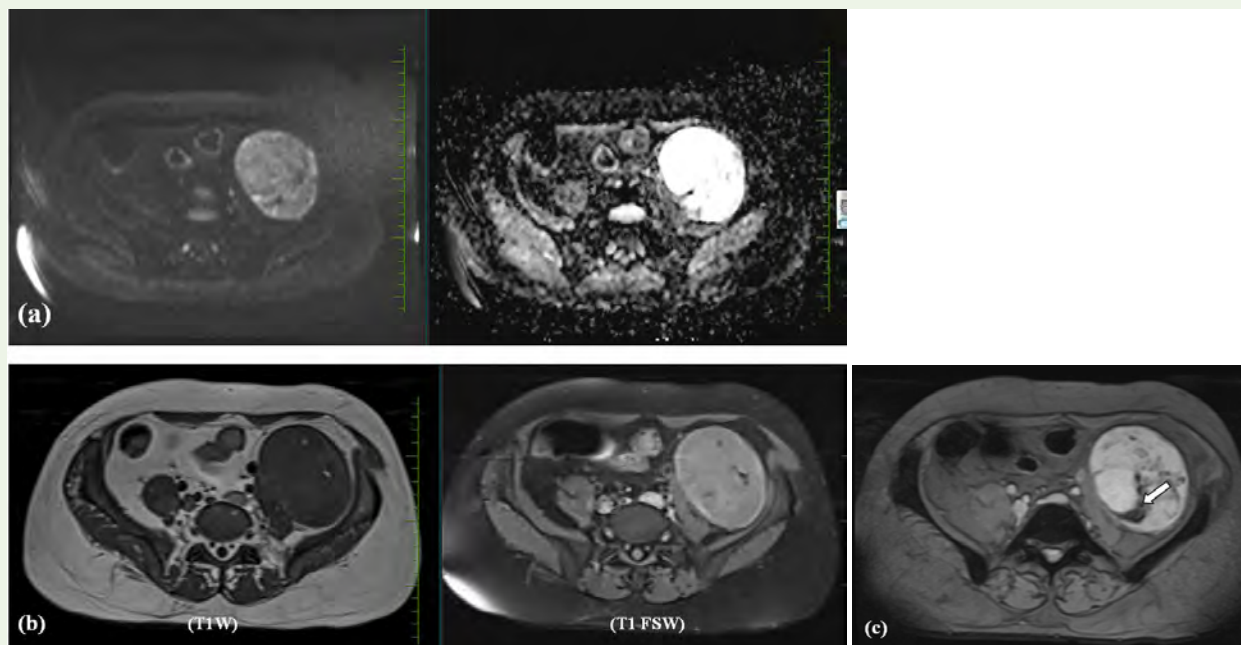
(a) The lesion shows facilitated diffusion with few areas of true diffusion restriction on DWI and (b) few T1 hyper-intense foci which suppress T1 Fat saturation images represent fatty foci and (c) focal areas of blooming noted on GRE imaging- s/o haemorrhage (arrowhead).
